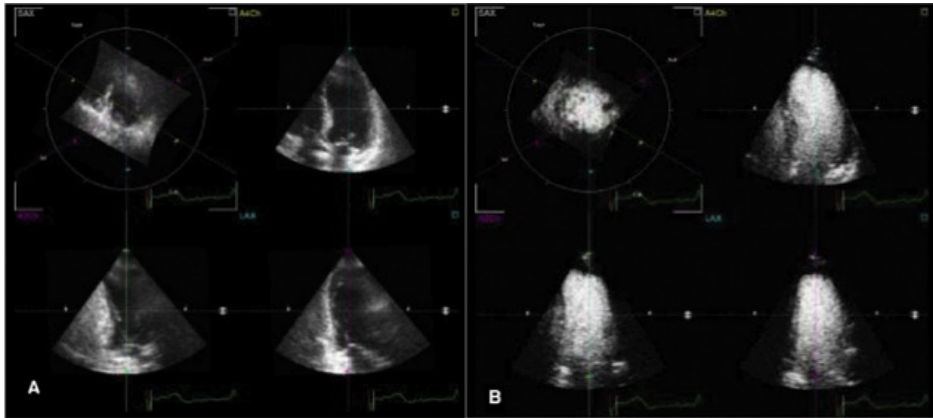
Panel A. Example of fair-quality echocardiogram during nonenhanced RT3DE. Panel B. Optimal LV chamber opacification and improved endocardial border definition during contrast-enhanced RT3DE in the same patient. The 3 apical views are shown with the 4-chamber view as a reference view in the top right and the 2- and 3-chamber views in the bottom left and bottom right, respectively. Top left: short-axis view.
